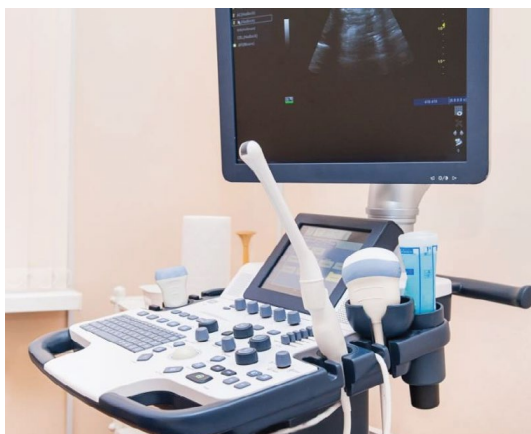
Represents the Ultrasound device.
